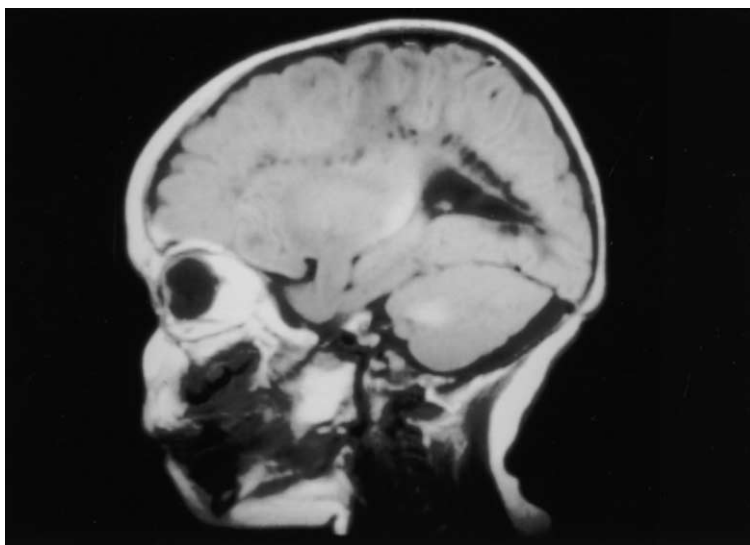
MRI of the sagittal region of the same child shows cystic periventricular leukomalacia. These changes are frequently caused by perinatal anoxia. The coronal views show similar periventricular involvement.
